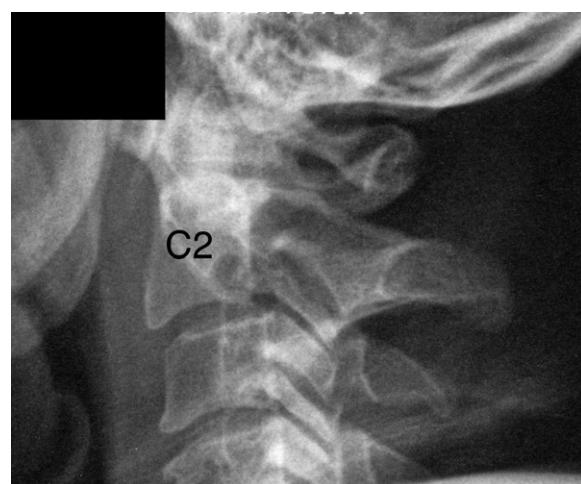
Upper cervical spine lateral plain X-ray image reported as showing anterior slip of C2 on C3 by approximately 3 mm, possibly related to recent bony trauma. Osteophytic lipping is seen at the C3–4 level.
